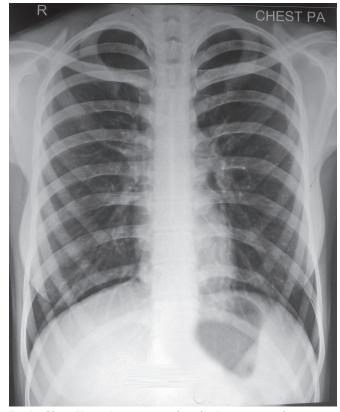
Chest X-ray (postero-anterior view) at presentation showing no pleuro-parenchymal abnormality
